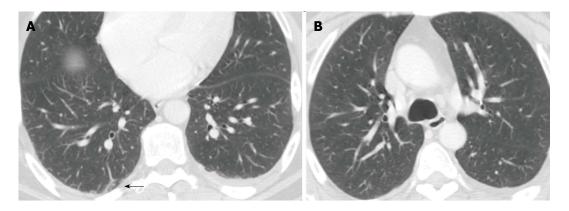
Chest computed tomography showing pulmonary lesions in the posterior region of the right lung (A) associated with left pulmonary embolism (B).
